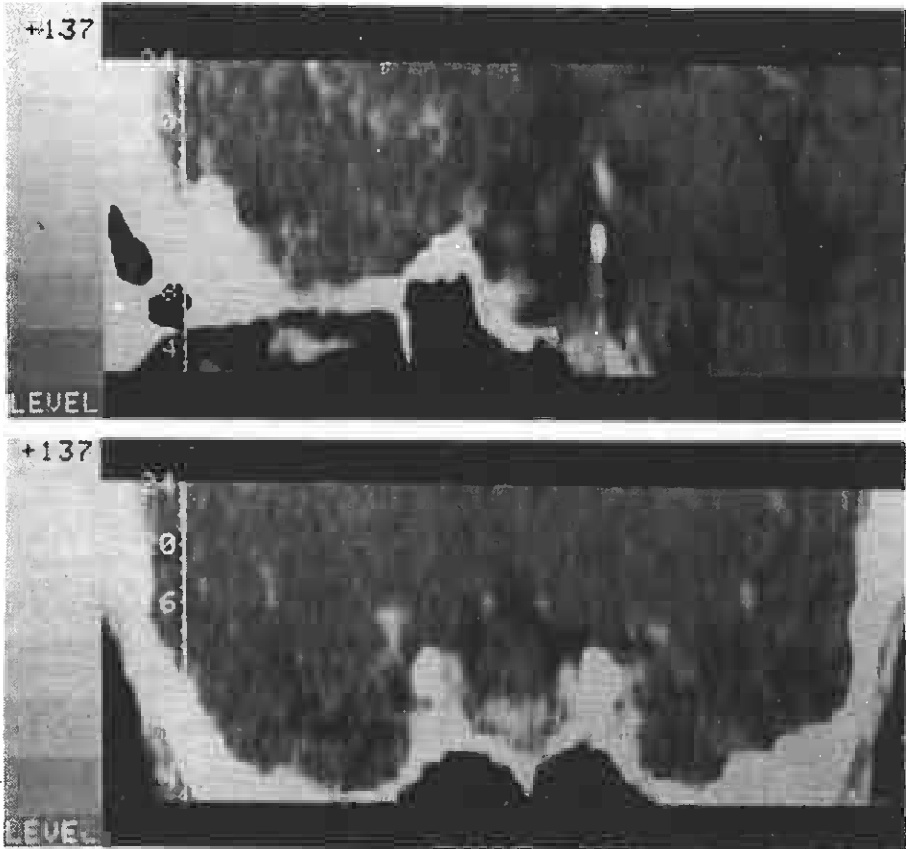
Sagittal (top) and coronal (bottom) reconstructions of CT scans in the same patient as shown in figure 2 after 5 months of treatment with bromocriptine. The prolactinoma has shrunk considerably.
